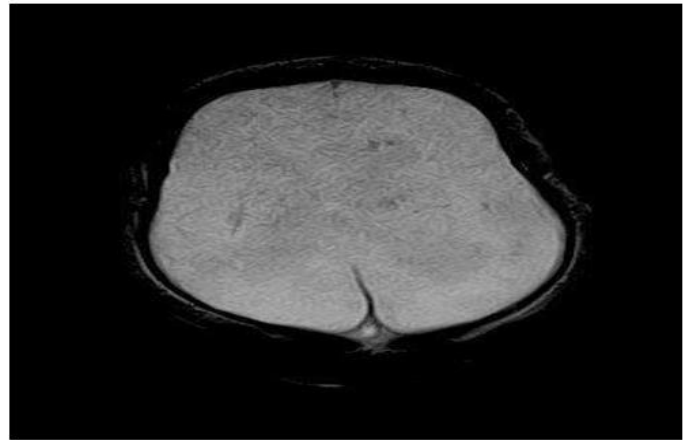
T1/T2/FLAIR Hyperintensity noted in bilateral centrumsemiovale in a preterm baby – HIE changes
